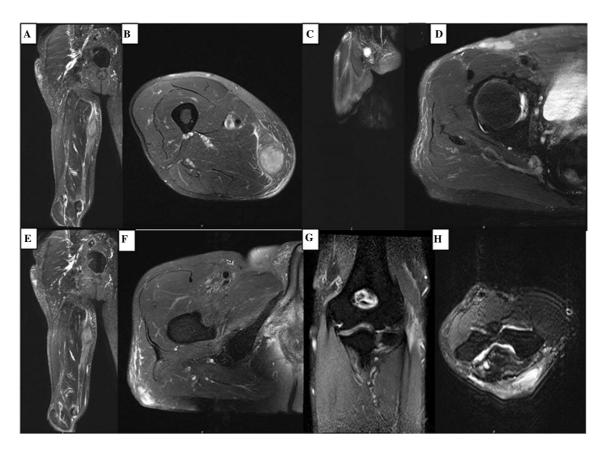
Skin and soft tissue abscesses at the right thigh, groin, buttock and the left elbow demonstrated on MRI on the febrile middle-aged man with disseminated nocardiosis. A/B: An 4 intramuscular abscess collection within the right gracilis muscle with surrounding edema. C/D: Small collection is noted within the subcutaneous fat overlying the right sartorius and iliacus muscle at the right groin region. E/F: A small collection within the subcutaneous fat overlying the postero-lateral aspect of the right gluteus maximus. G/H: Extensive area of subcutaneous hyperintense theta signal seen in the posterior aspect of the elbow joint; focal thick wall fluid collection with layering noted in the subcutaneous layers.
